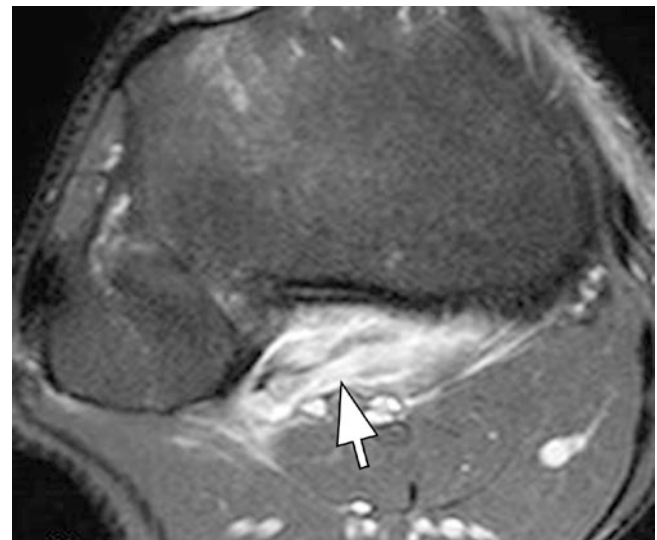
Popliteus myotendinous strain. Axial T2-weighted image with fat suppression. Increased signal involving the popliteus myotendinous junction and muscle (arrow)
